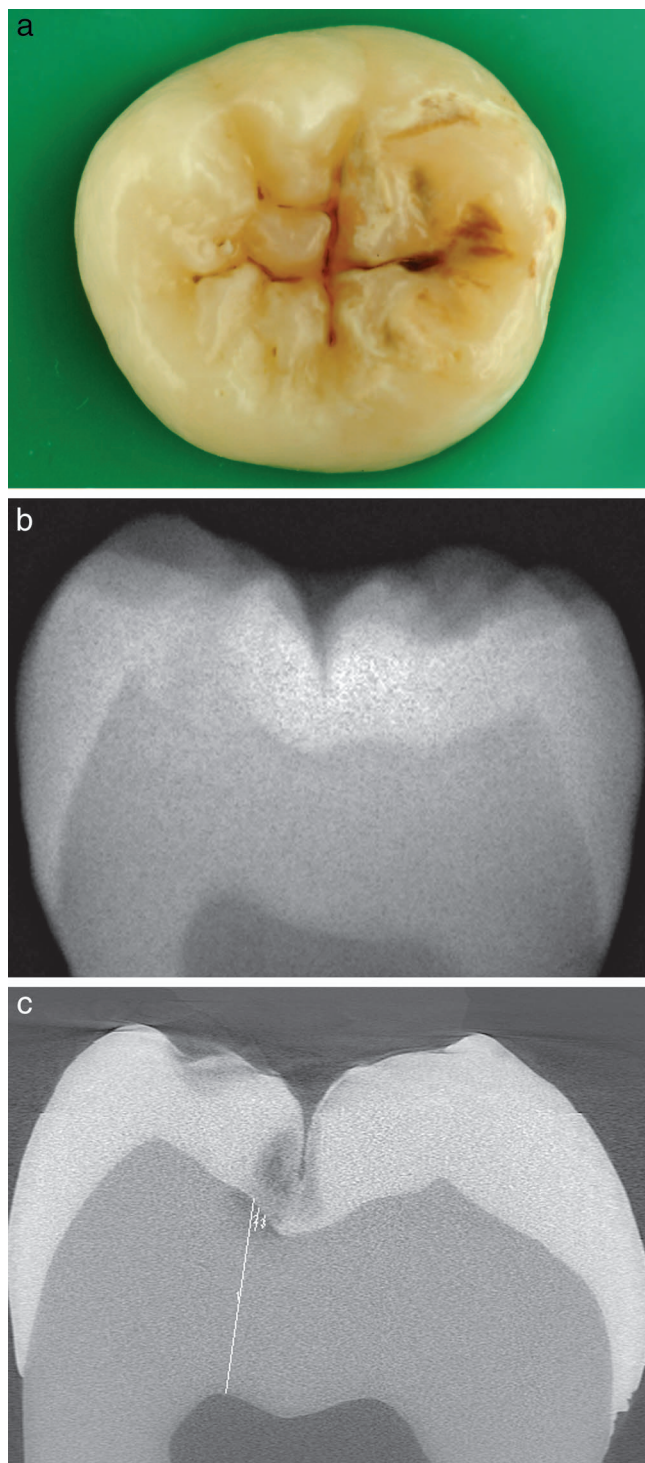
(a): The occlusal lesion of the central fissures shows a white-brown lesion with dentin exposure that was also detectable with a blunt probe. After use of the Universal Visual Scoring System (UniViSS), preventive measures only were recommended for this tooth. (b): No dentin caries was detectable in the x-ray. The tooth was classified as enamel caries (D0-2 after Marthaler). (c): The micro-computed tomography slice reveals a dentin caries lesion near the enamel-dentin junction (D3 after Marthaler). A maximum score of 1.11 was calculated according to the Caries Extension Index.
